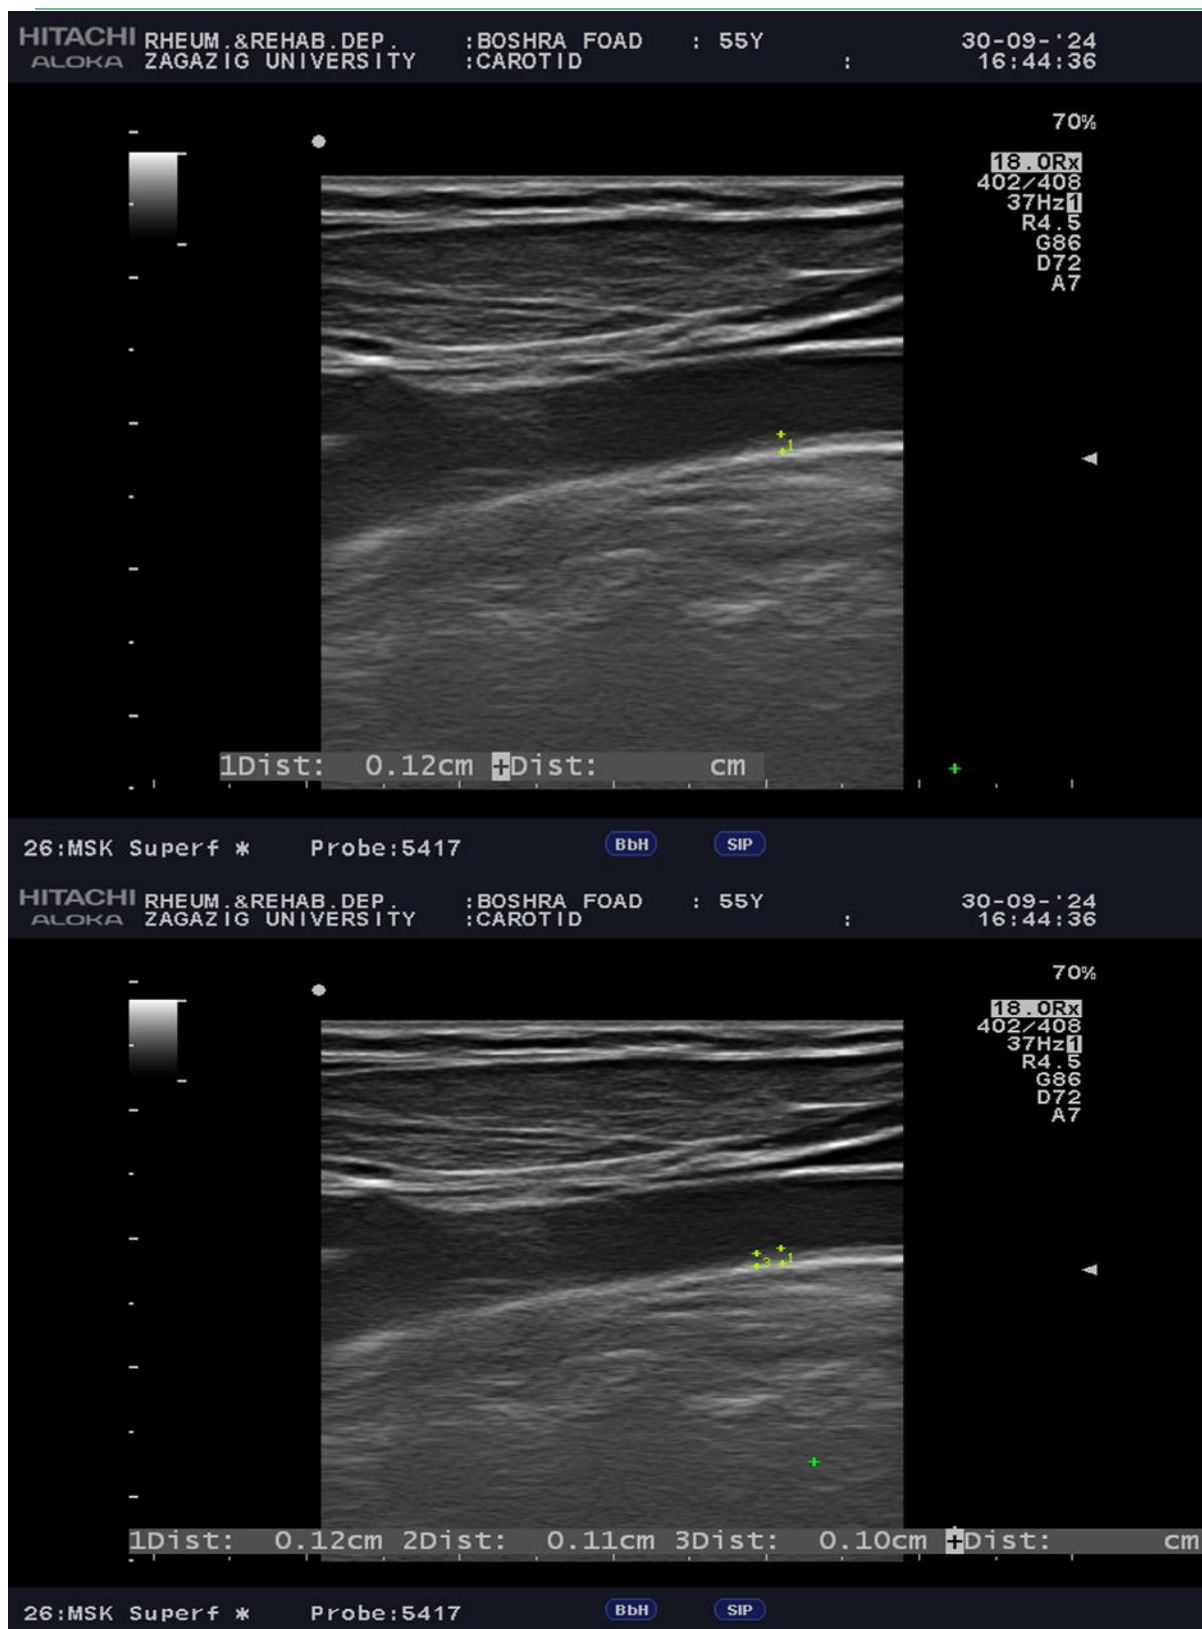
SLE Female patient 55 years old , ultrasonography showed CIMT of right and left common carotid artery (1.1mm and 1.2 mm).
